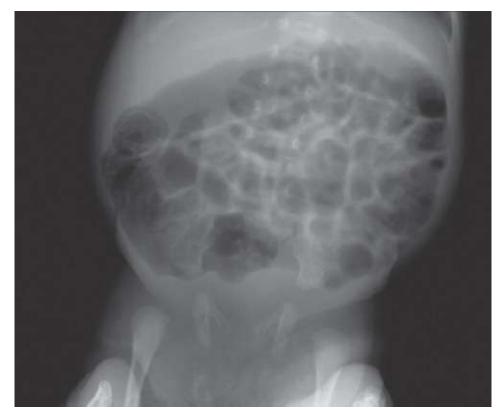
Radiographic findings of necrotizing enterocolitis. Pneumatosis intestinalis is visualized in the right upper quadrant.
